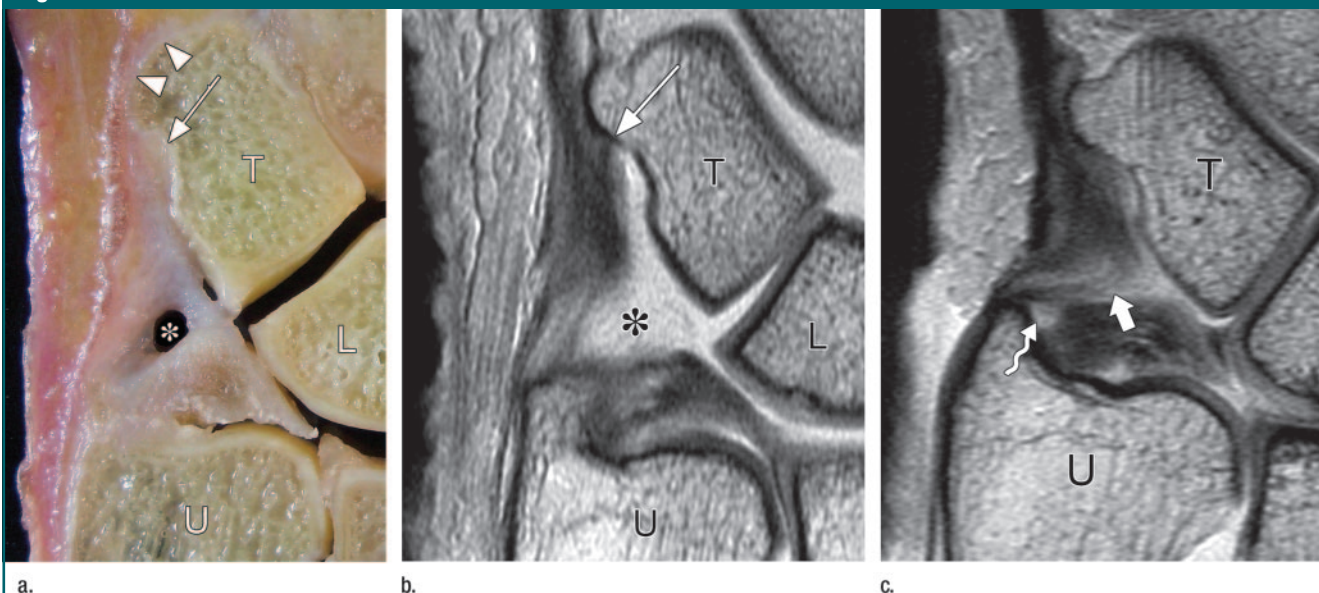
Wide-opening UMH type with respect to the entrance to the prestyloid recess. (a) Anatomic section and (b, c) intermediate-weighted MR images obtained with the wrist in neutral position (b) and maximal ulnar deviation (c) are shown. *T* = triquetrum, *U* = ulna. In a and b, the entrance (asterisk) to the prestyloid recess is well shown. *L* = lunate bone. In b, the entrance seems to be wider, probably because of its distention after injection of the contrast agent. In c, the entrance (straight arrow) to the prestyloid recess is almost totally collapsed; the recess is partially visible at the tip of the ulnar styloid process (wavy arrow). In addition, the distal insertion of the UMH (thin arrow in a and b) is well shown at the ulnar aspect of the triquetrum. The fibers inserting into the ulnar aspect of the hamate bone extend around the distal triquetrum (arrowheads in a). A complete tear of the lunotriquetral ligament is also seen.
